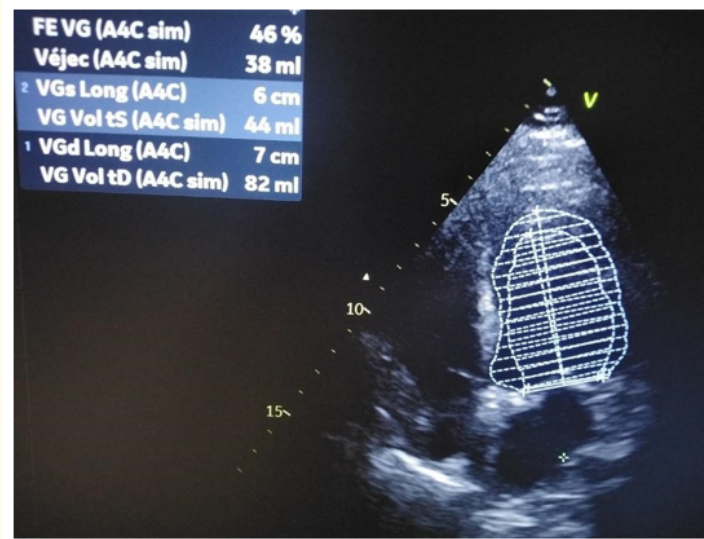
Echocardiography showing systolic dysfunction.
